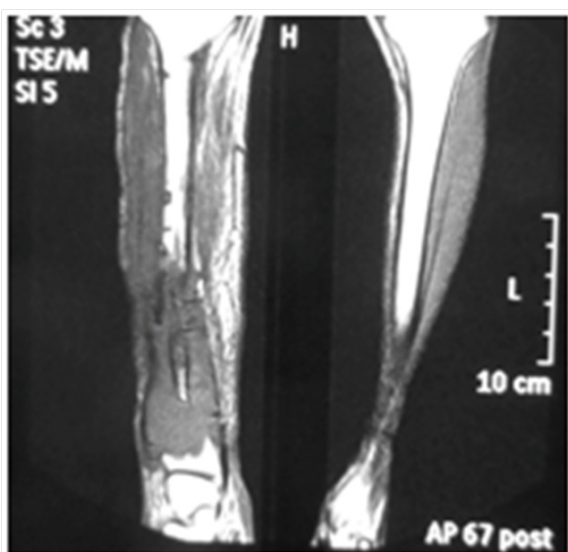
MRI coronal cut of the leg showing local recurrence in case 2.
